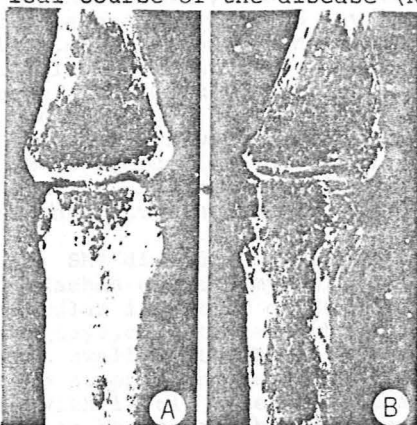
Sequential roentgenograms in patient before (A) and six months after (B) the development of the RSDS in the left hand (see text). Note the development of reactive new bone and a "crumbling" appearance along with resorption of bone in the endosteal, intracortical and subperiosteal areas
